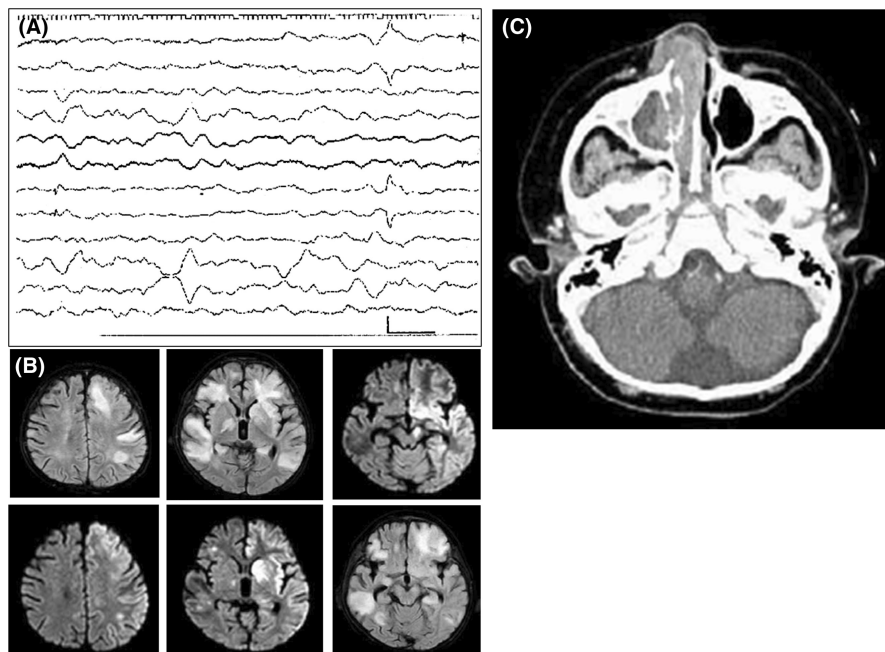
(A) Diffuse 50-150 μ V, 1-3 Hz slow waves predominate in the occiput in EEG. (B) Newly sporadic T2 and FLAIR-high signal areas are observed in the cerebral cortex, white matter, basal ganglia, and midbrain. (C) CT revealed a filling mass with bone destruction in the right nasal cavity, which extended to the right maxillary sinus and nasopharynx.
